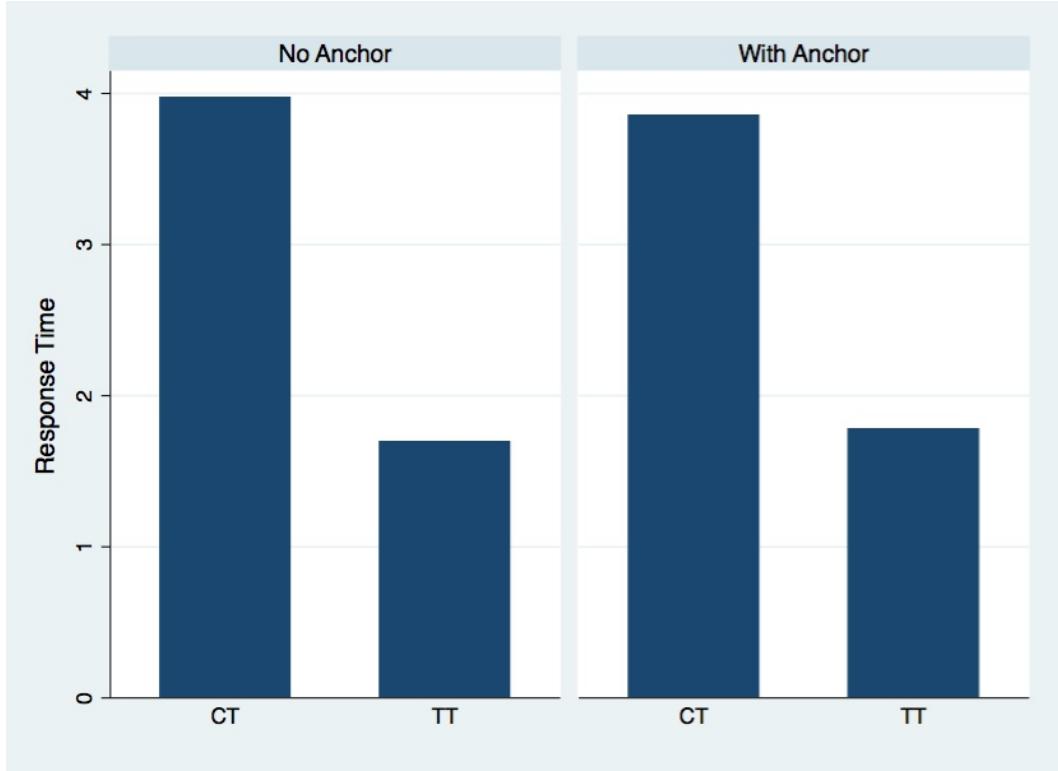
Average response time for Control Treatment (CT) and Time pressure Treatment (TT) for games with and without anchor
